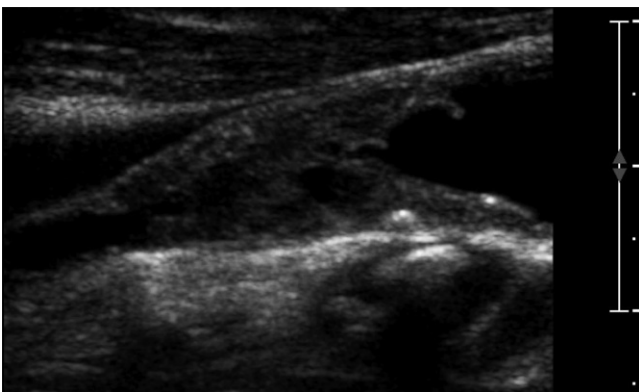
Gray scale ultrasound of the right ICA demonstrates irregular plaque narrowing the lumen.
